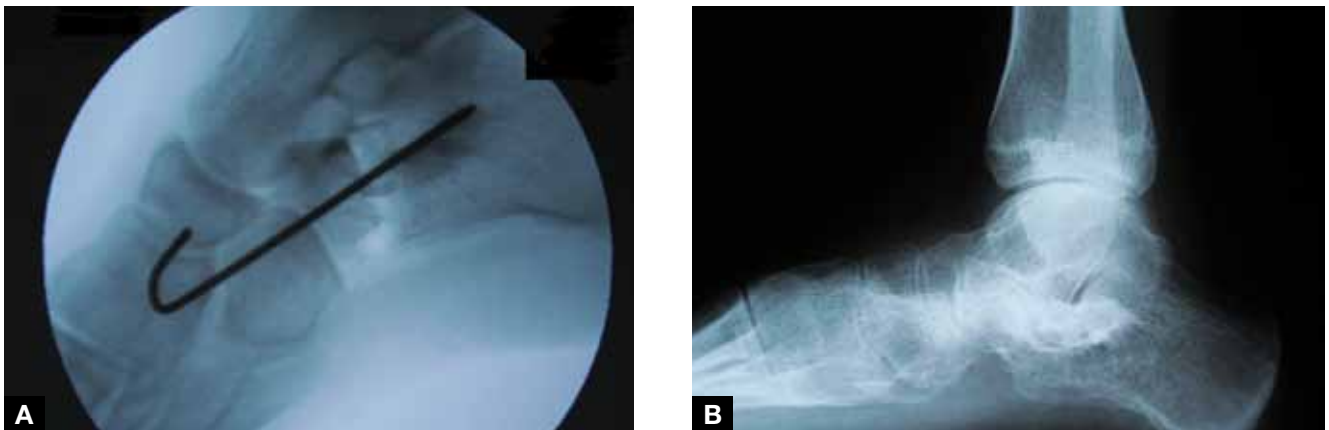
(A) Intraoperative radiograph of a lateral column lengthening. Note the good overall position of the allograft within the calcaneal osteotomy. (B) Postoperative radiograph taken at 5 months. The allograft has completely incorporated into the surrounding host bone with sclerosis as determined by incorporation and trabecular bridging from host bone to allograft bone on both sides of the allograft.
